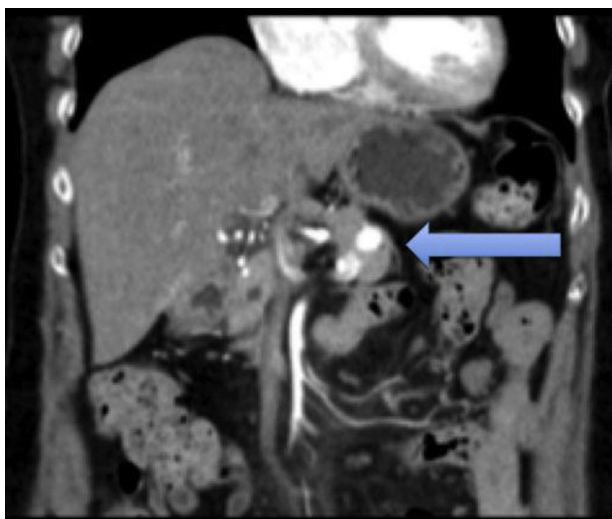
Coronal reconstruction of computed tomography of the abdomen, with intravenous contrast. A hypervascular lesion of 11 mm diameter is observed in the body of the pancreas, which quickly presents contrast lavage.
